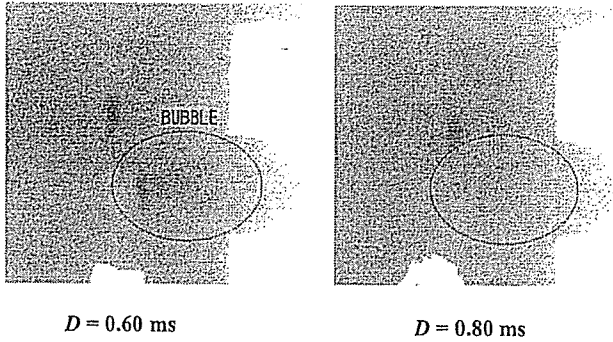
Delayed radiography of the cavitation bubble cloud induced by underwater shock wave focusing in living frog.
